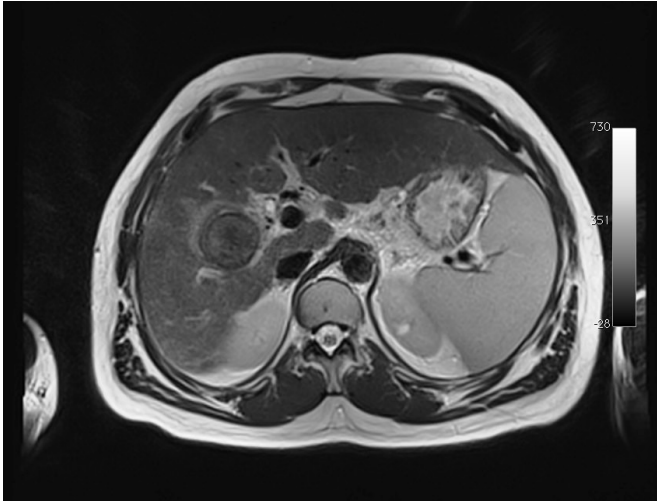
Liver MRI – T2 axial plane. After cryotherapy.
